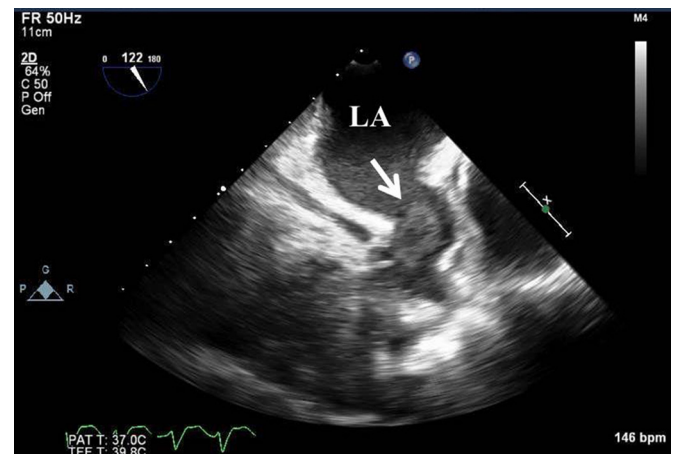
Two-dimensional transesophageal echocardiography showing a left atrial appendage thrombus (arrow). LA, left atrium.
